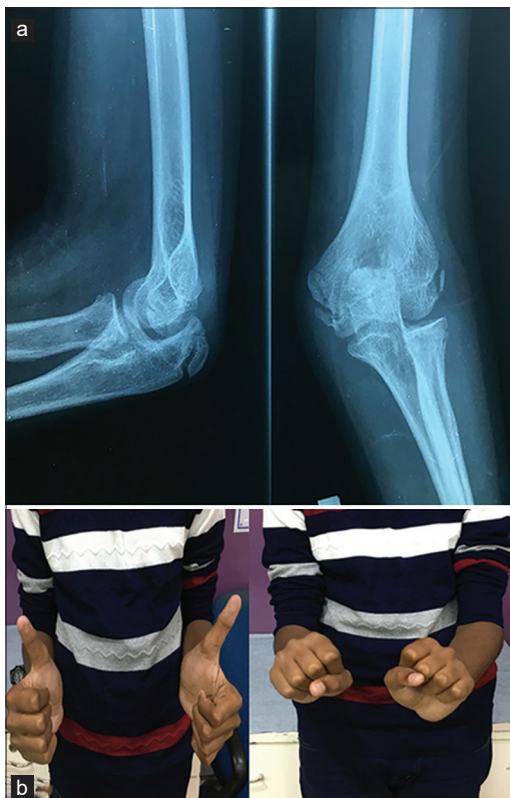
(a) Radiograph anteroposterior and lateral at 1-year follow-up showing anatomical position of the radial head. (b) Clinical photograph showing the full range of motion with the normal function of the radial nerve like the uninjured side.
